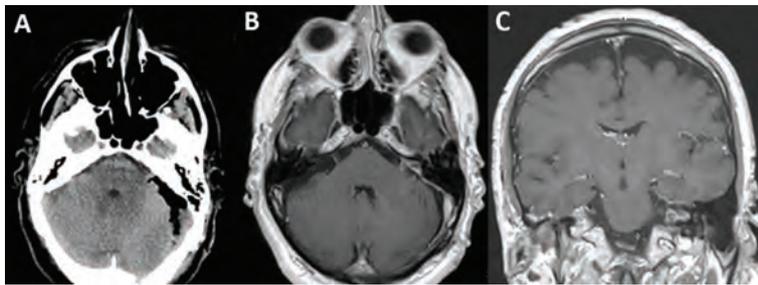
Postoperative imaging of the patient. (A) immediate postoperative CT of the head following surgery. (B) Axial and (C) coronal postoperative post-contrast head MRI showing resection of the tumor.
